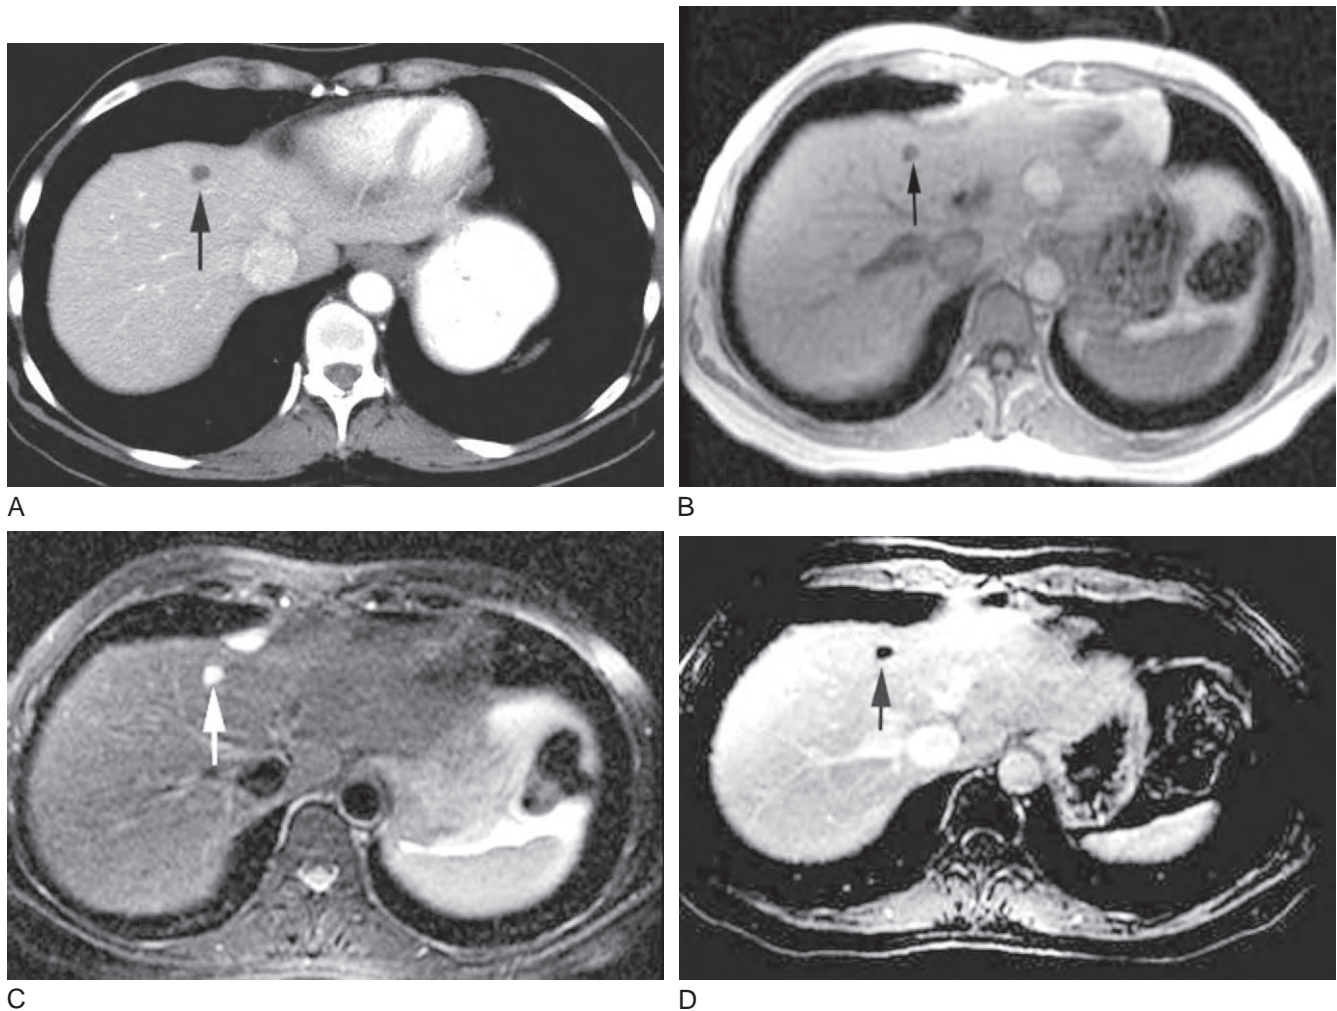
A small incidentally detected simple cyst on CT and MR imaging in a patient with no history of malignancy or chronic liver disease. Transverse contrast-enhanced CT image (A) shows a 1-cm hypodense mass in the medial segment of the left lobe (*arrow*). The mass is too small to be accurately characterized. Transverse T1-weighted (B) and T2-weighted (C) images of the liver show the mass (*arrows*) to be hypointense relative to liver on T1-weighted imaging and markedly hyperintense on T2-weighted imaging. The mass (*arrow*) does not enhance on the transverse gadolinium-enhanced image (D).
